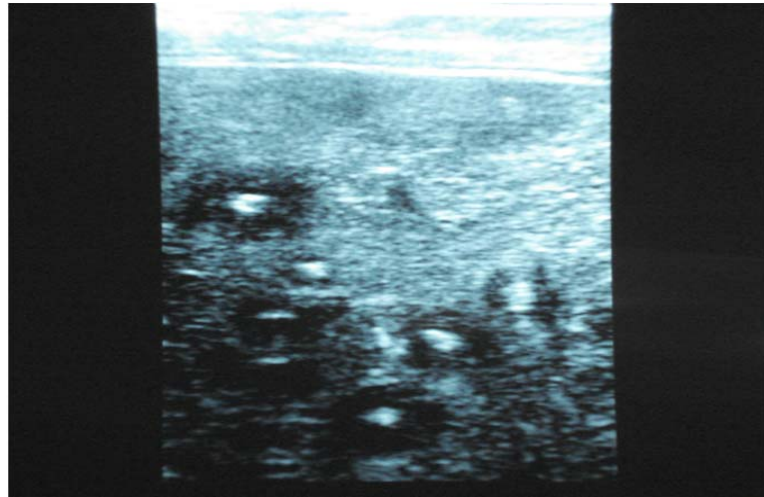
Hepatosplenic candidiasis lesions detected by abdominal ultrasound in a girl undergoing allogeneic stem cell transplantation.
